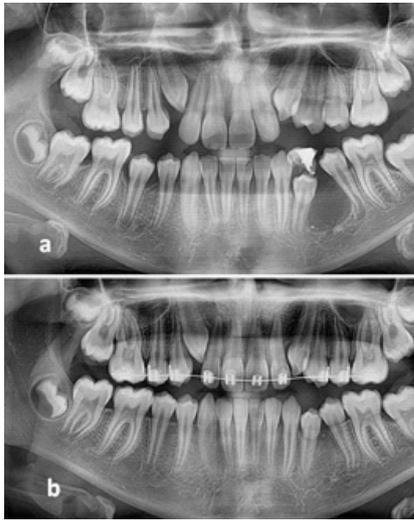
Preoperative radiograph (a) and post operative (b) revealed a good amount of regeneration, repair at the site of cystic cavity.
